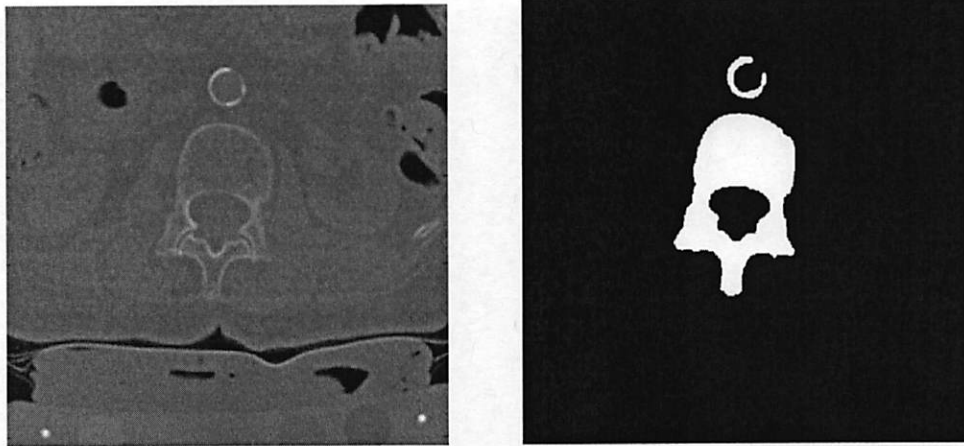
An example slice from the CT dataset, and its segmented vertebral mask.
